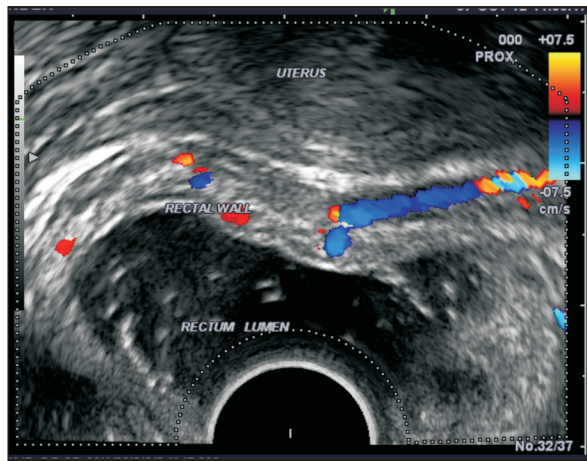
The radial ultrasound of rectum showed vascular signal in the submucosa of anterior wall of rectum
